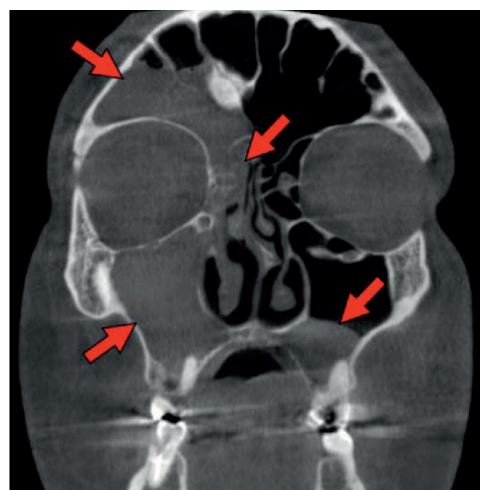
CBCT scan revealing unilateral pansinusitis with obstruction of the maxillary, ethmoid, and frontal sinuses
